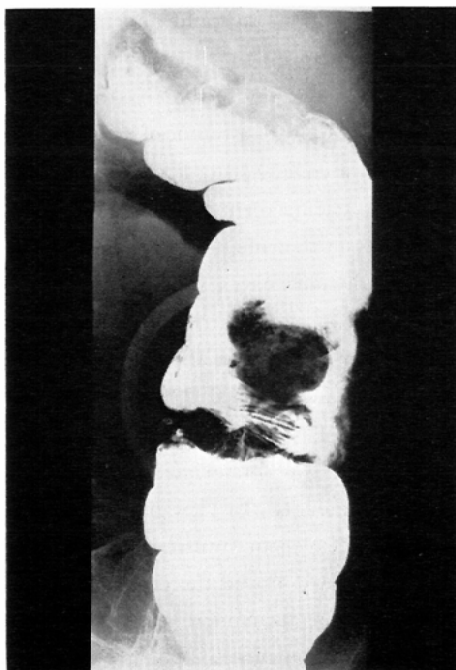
Case 2. Roentgenogram of the colon after a barium meal (prone position). Compression reveals tumor shadow with a smooth margin and a coiled spring-like shadow in the colic wall medial to it.
